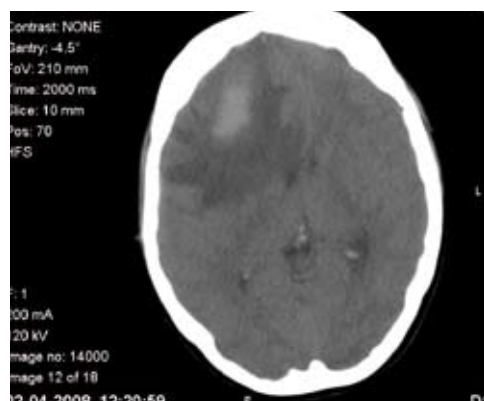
Cerebral - CT showing reduction of the hemorrhagic lesion.
